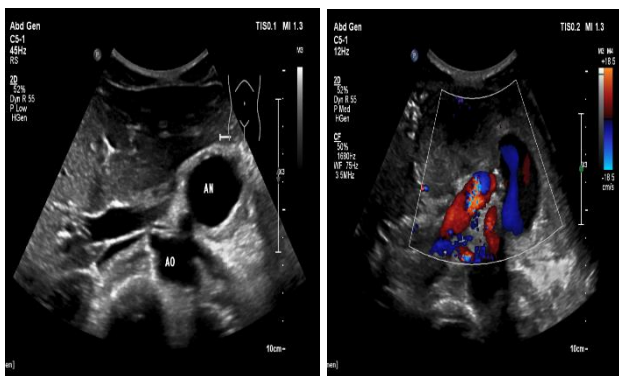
USG abdomen demonstrating the aneurysm (an) and the abdominal aorta (AO). Doppler mode showing direction of flow of flood.
